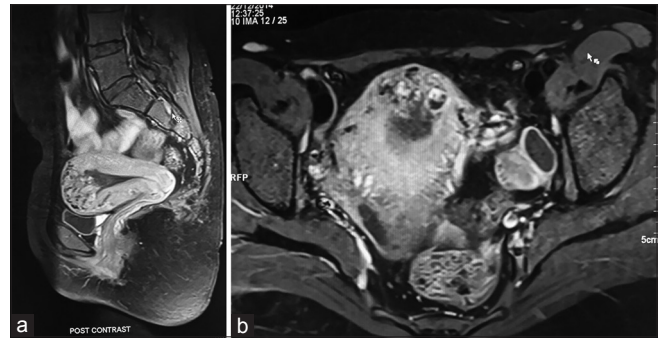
(a and b) Postgadolinium-enhanced magnetic resonance imaging shows heterogeneously enhancing trophoblastic tissue of choriocarcinoma involving endometrium and invading the myometrium
